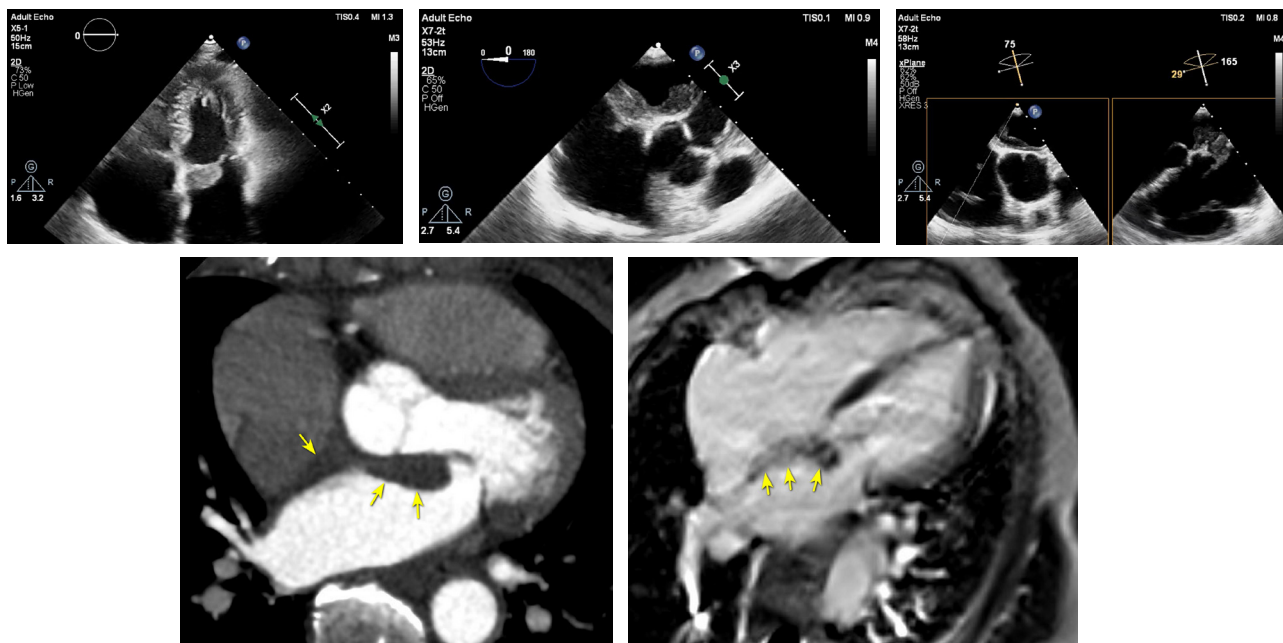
(A) Thoracic multislice computed tomography demonstrating a heterogeneous, hypodense, lobulated mass originating from the interatrial septum, extending into the mitral-aortic intervalvular fibrosa, and projecting into the atrial cavity. (B) Cardiac magnetic resonance imaging showing the mass as iso-to mildly hyperintense on T1-weighted imaging and hyperintense on T2-weighted imaging, with mild heterogeneous enhancement on contrast-enhanced sequences
